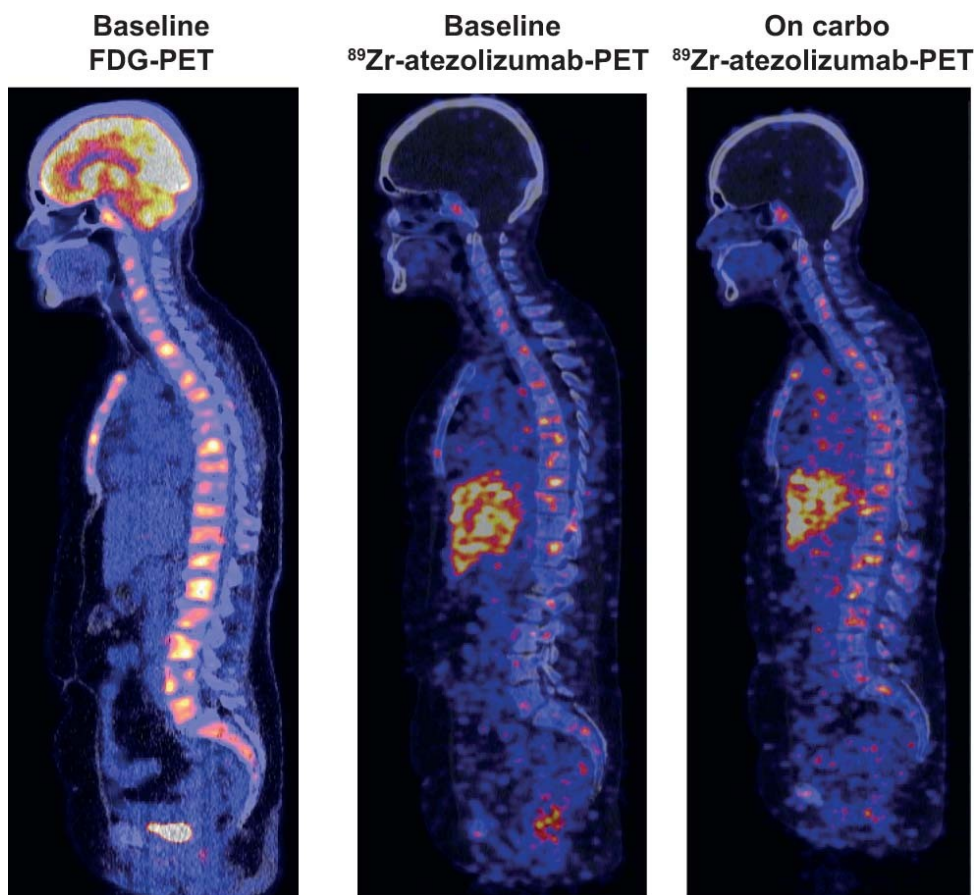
Exploratory analysis of the use ^{89}Zr -atezolizumab-PET to evaluate PD-L1 distribution in ILC patients. Representative images of one patient imaged with FDG-PET and ^{89}Zr -atezolizumab-PET. Left panel represents lateral view of baseline FDG-PET, the middle panel represents the lateral view of baseline ^{89}Zr -atezolizumab-PET and the right panel ^{89}Zr -atezolizumab-PET after two cycles of carboplatin.
